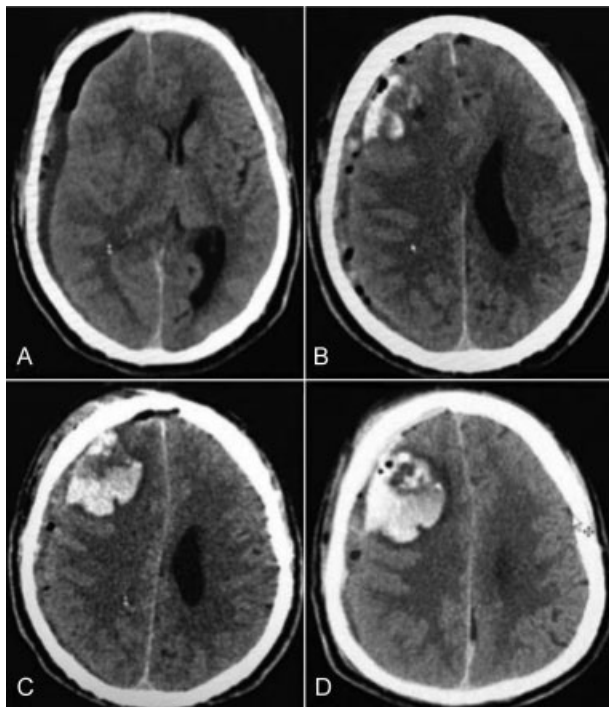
(A) CT of the head done after 4 hours of burr hole evacuation of right chronic subdural hematoma showing evacuation of subdural hematoma (B) with appearance of ipsilateral frontal hematoma away from burr hole site. (C) CT of the head done after 24 hours showing enlarging right frontal hematoma. (D) CT of the head done after 36 hours showing significant increase in hematoma size with midline shift. CT, computed tomography.
